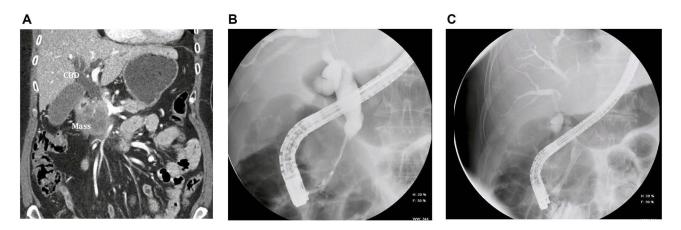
A 67-year-old woman presenting with dyspepsia, weight loss and jaundice. CT showed a 6 cm mass in the head of the pancreas with vascular involvement (SMV > 270°, SMA >120%) compressing the distal CBD (A). Both EUS-FNB and ERCP with brushings confirmed non-resectable pancreatic adenocarcinoma (B). A 10mm USEMS 4cm was inserted to provide drainage before neoadjuvant chemotherapy (C).
